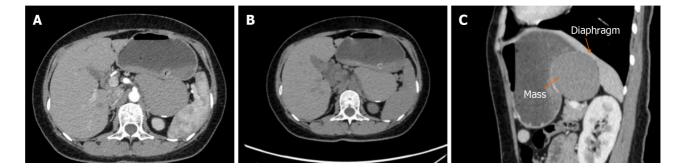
Imaging at admission. A: An enhanced computed tomography scan demonstrated a 10.1 cm × 6.1 cm mass. The mass was present in the posterior part of the stomach between the spleen and the left kidney; a large, slightly high-density swelling shadow with uniform internal density was shown; and a small calcification shadow could be seen at the rear. The computer tomography (CT) value was approximately 70 HU, and the gastric wall was compressed and changed; B: Noncontrast CT image; C: It can be clearly seen from the sagittal position that the diaphragm was compressed by the mass.
